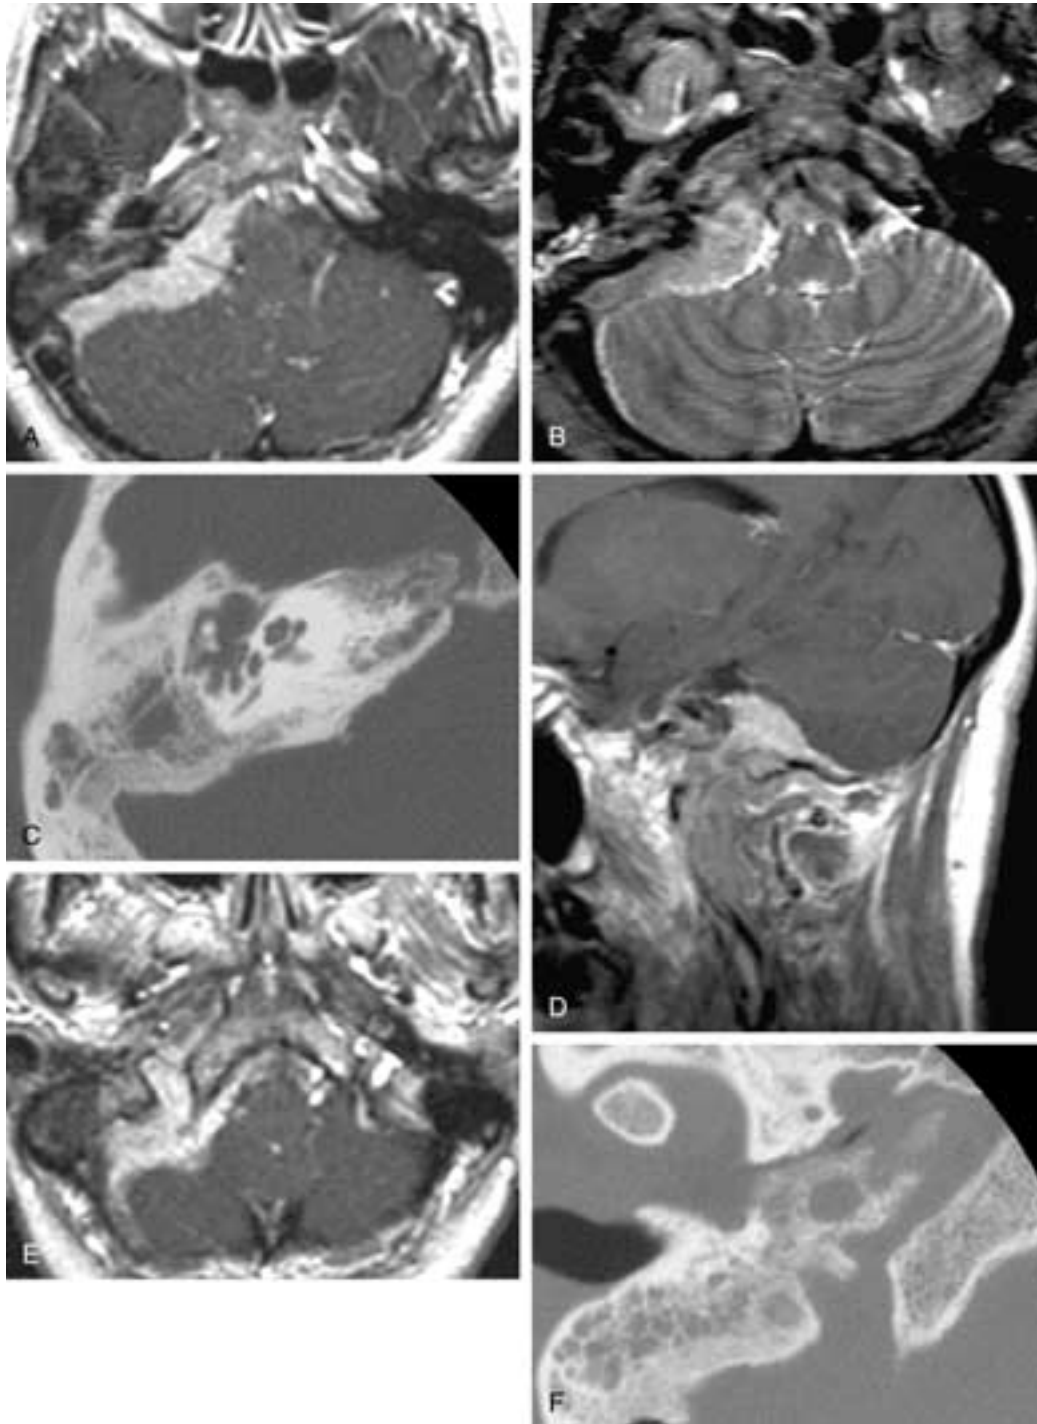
Jugular fossa meningioma. A, T1-weighted postgadolinium image. The broad dural-based tumor occupies the CPA cistern. Mastoid cell aeration is obliterated, and some enhancement is seen in the temporal bone as well. B, T2-weighted image at the same level. The tumor is isointense with gray matter. Note the signal changes in the temporal bone. C, CT bone window. Note the loss of sharpness of the cortex and sclerosis of the infiltrated bone. D and E, T1-weighted postgadolinium images. The meningioma extends through the jugular foramen. F, CT bone windows. Hyperostosis, new bone formation in the jugular foramen.
